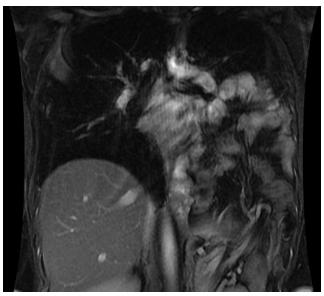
Coronal FIESTA (axial fast imaging employing steady-state acquisition). MRI
